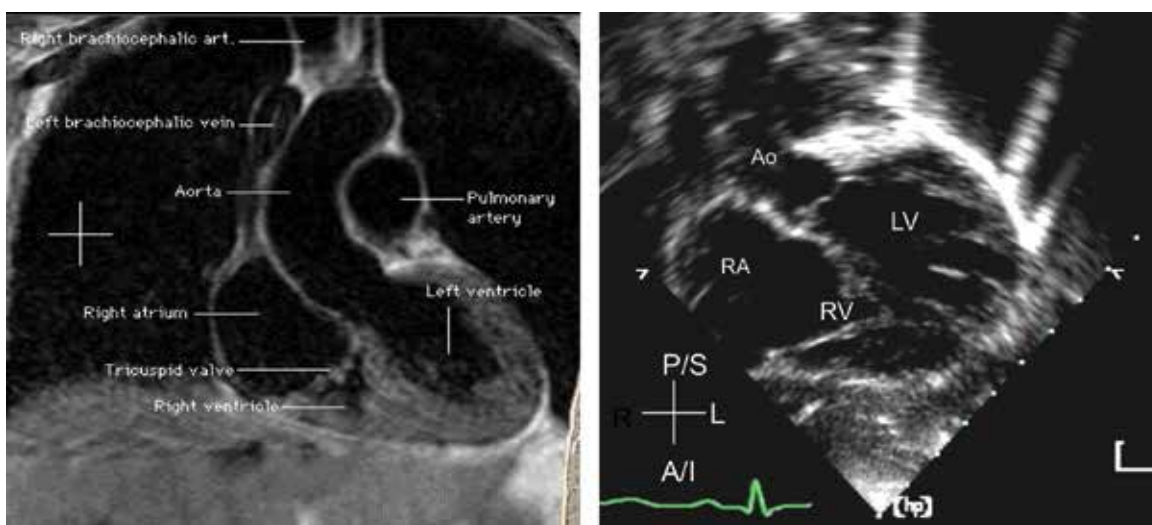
A comparison between a MRI scan in the coronal plane with an echocardiogram in the sub-xiphoid long-axis view. Anatomically correct display of structures allows a better orientation at all times while performing an echocardiogram
